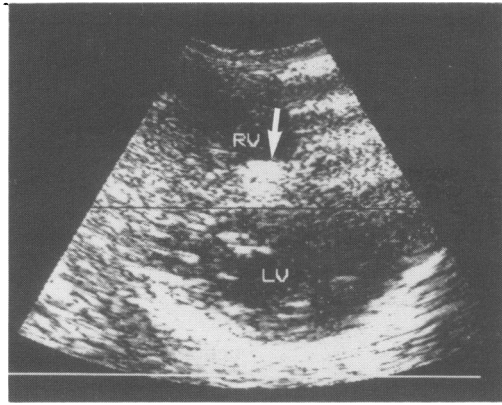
Ultrasound parasternal view of the heart showing the mass (arrow) in the right ventricle on the septum. LV=left ventricle, RV=right ventricle.
